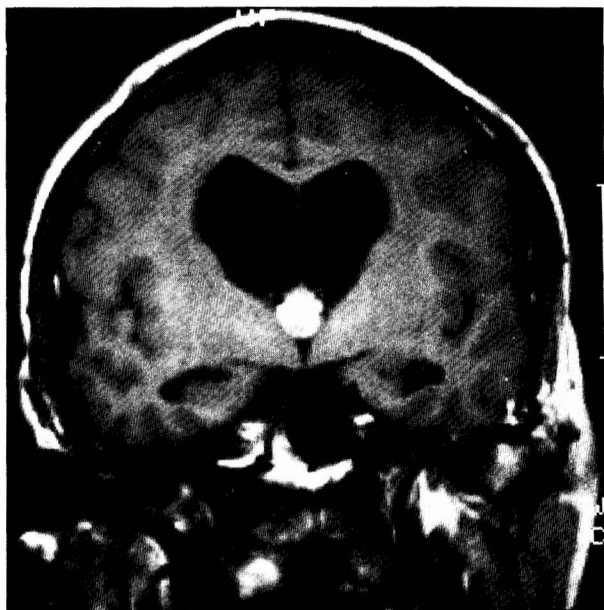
MRI scan shows enlarged lateral ventricles and a homogenous lesion in the anterior third ventricle, typical of a colloid cyst.
